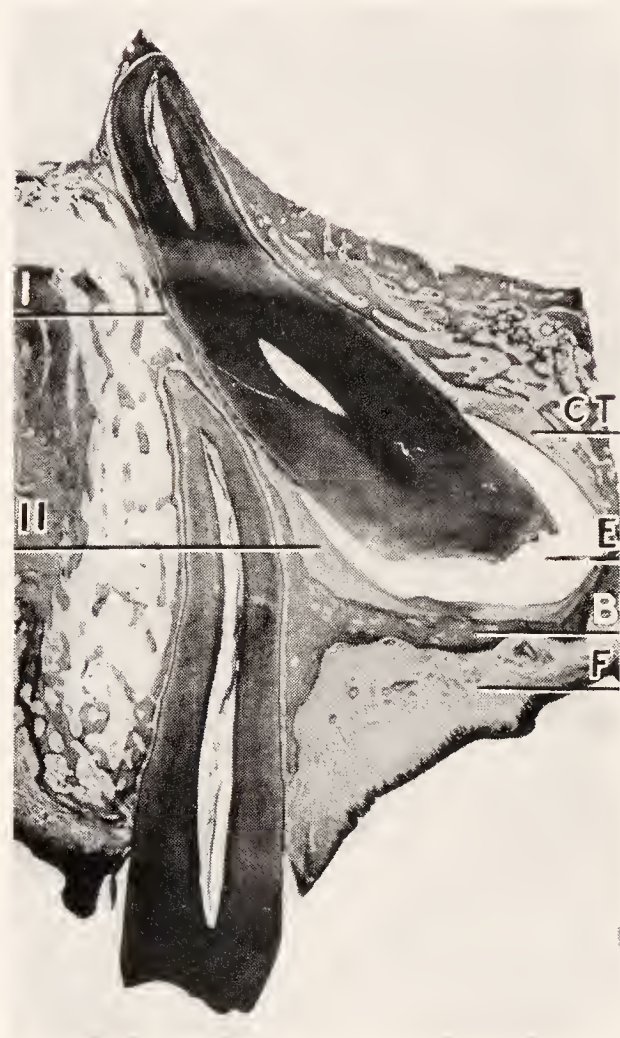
Mesio-distal section through an impacted upper cuspid and an erupted first bicuspid. E, enamel of impacted cuspid; CT, connective tissue capsule surrounding the crown of the cuspid; B, bone covering the cuspid; F, fibrous tissue of the edentulous ridge overlying the impacted cuspid. Higher magnifications of areas I and II will be shown in Figs. 327 and 328. (Gottlieb, *Fortschr. d. Zhk.*, courtesy of Georg Thieme, Leipzig.)
